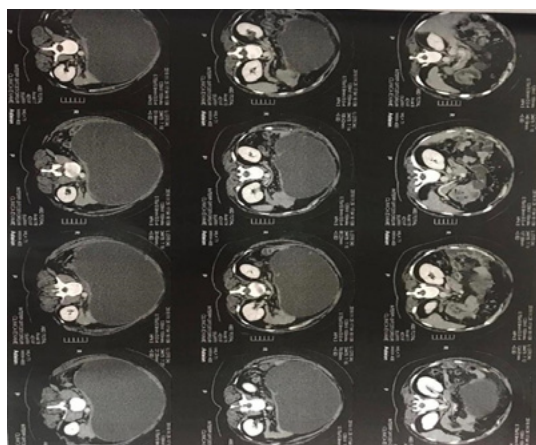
Axial Computed Tomography (CT) section of the abdomen, with compression of viscera on posterior wall of the peritoneal cavity.
